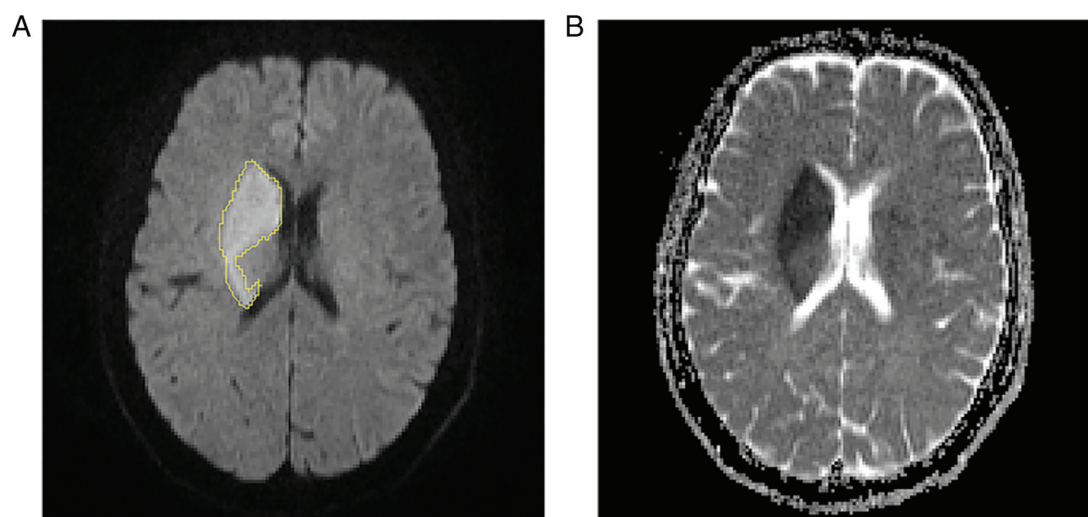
Manual delineation of the infarct lesion in a DWI map (B=1,000) by referring to the ADC map of the same cross section. (A) Outline of the DWI lesion. (B) ADC map corresponding to DWI slice. DWI, diffusion-weighted imaging; ADC, apparent diffusion coefficient.
